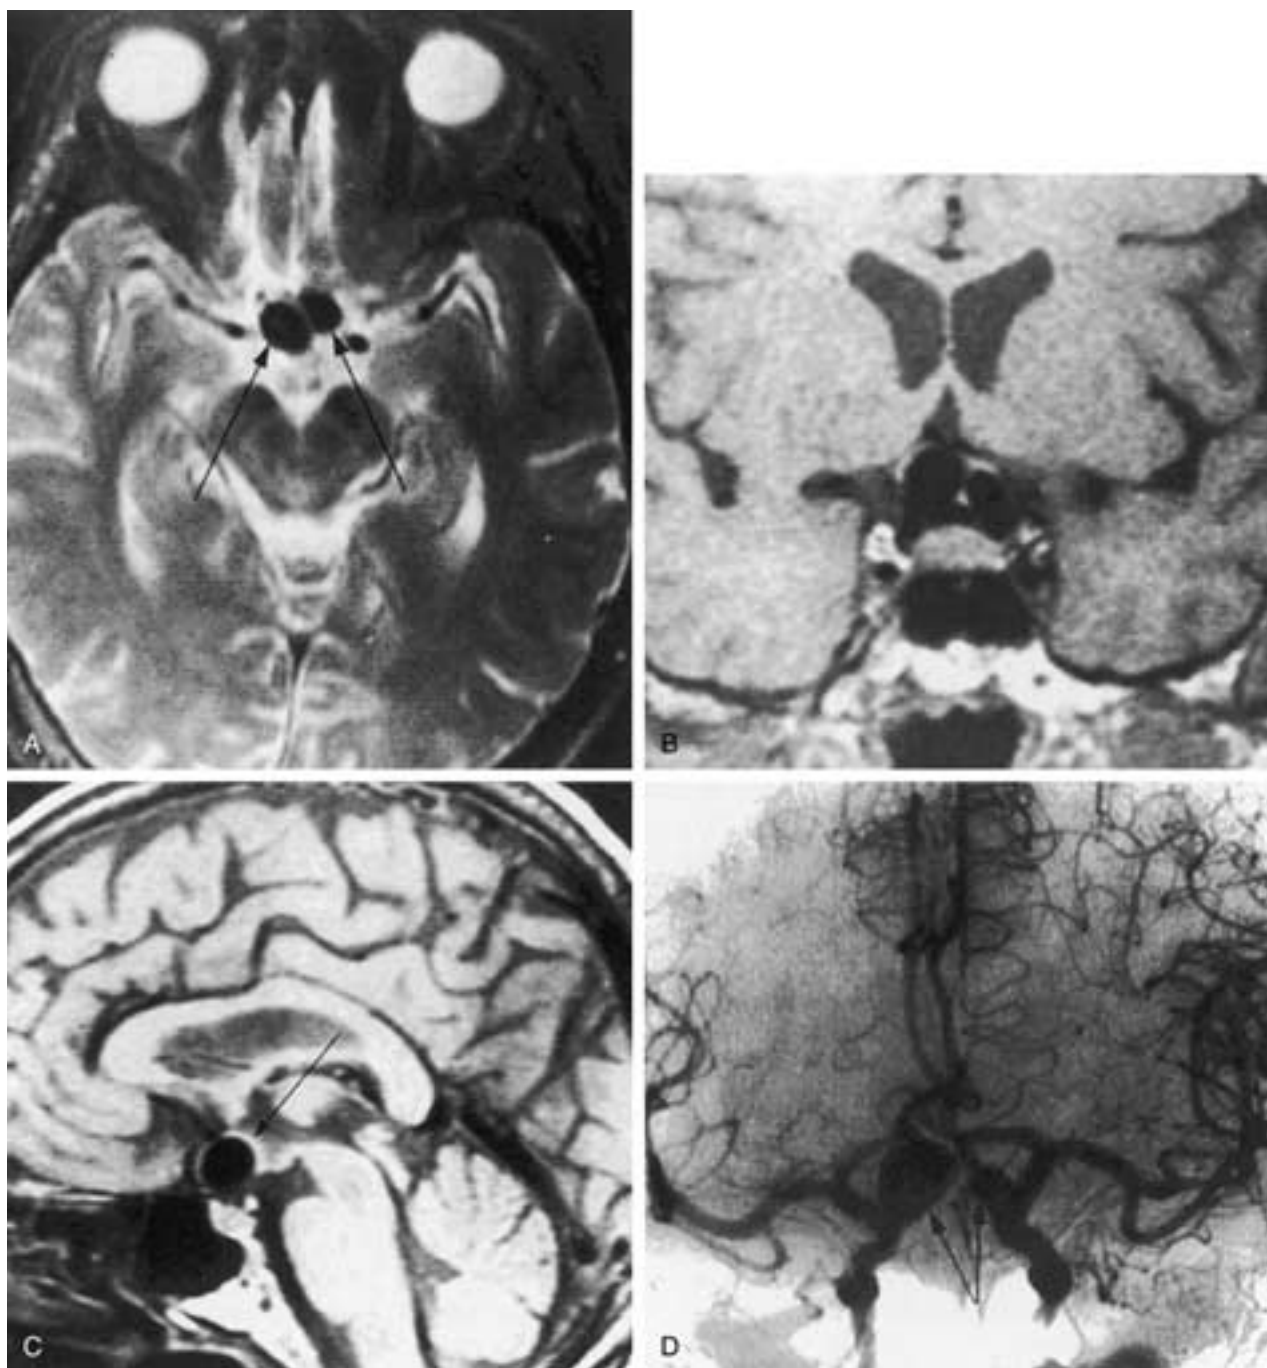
Bilateral ophthalmic artery aneurysms presenting with bitemporal hemianopsia. A, Axial T2-weighted image shows two areas of hypointensity (*arrows*) in the suprasellar cistern consistent with aneurysms. B, Coronal T1-weighted image shows two hypointense lumens of aneurysms projecting medially from the region of the internal carotid arteries and compressing the optic chiasm bilaterally. C, Sagittal T1-weighted image shows a larger aneurysm as a hypointense flow void and depicts the aneurysm's relationship to the chiasm (*arrow*), which is compressed from below. D, AP right and left carotid arteriogram subtraction films superimposed to show the relationships of both ophthalmic artery aneurysms, which project medially (*arrows*).
